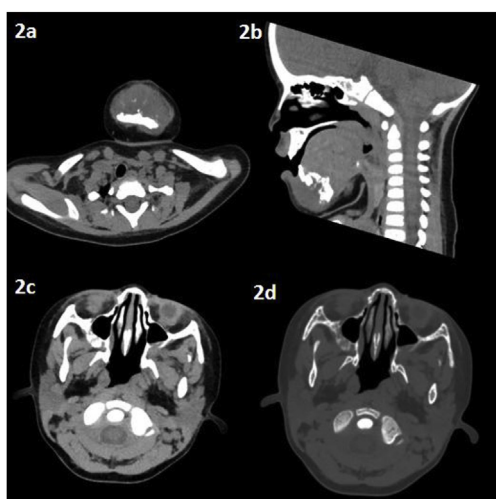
CT images after two chemotherapy cycles. 2a and 2b The tumor around maxillary shrunk in the size. 2c Mass in left maxillary sinus shrunk. 2d Mass in right superior wall of orbit stabilized.
